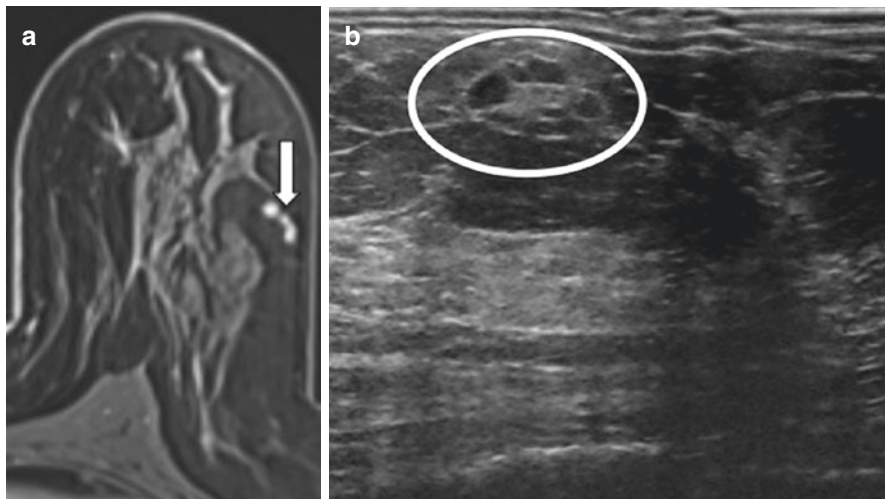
Known cancer as a landmark. (a) Axial T1W post-contrast image. (b) MRI-directed US from right breast. Sixty-four-year-old woman with known right breast invasive ductal carcinoma (*arrow*) found on extent of disease MRI to have an irregular enhancing mass (*circle a*) medial to the known malignancy. Using the known malignancy as a landmark, a subtle sonographic correlate (*circle b*) was identified. Biopsy demonstrated a second area of invasive ductal carcinoma.
